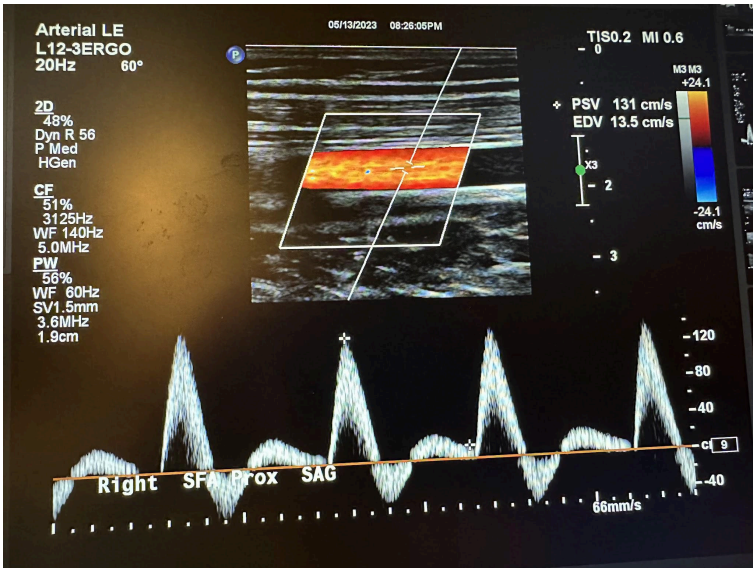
Sagittal image of the right proximal superficial femoral artery with color Doppler and waveform analysis.
